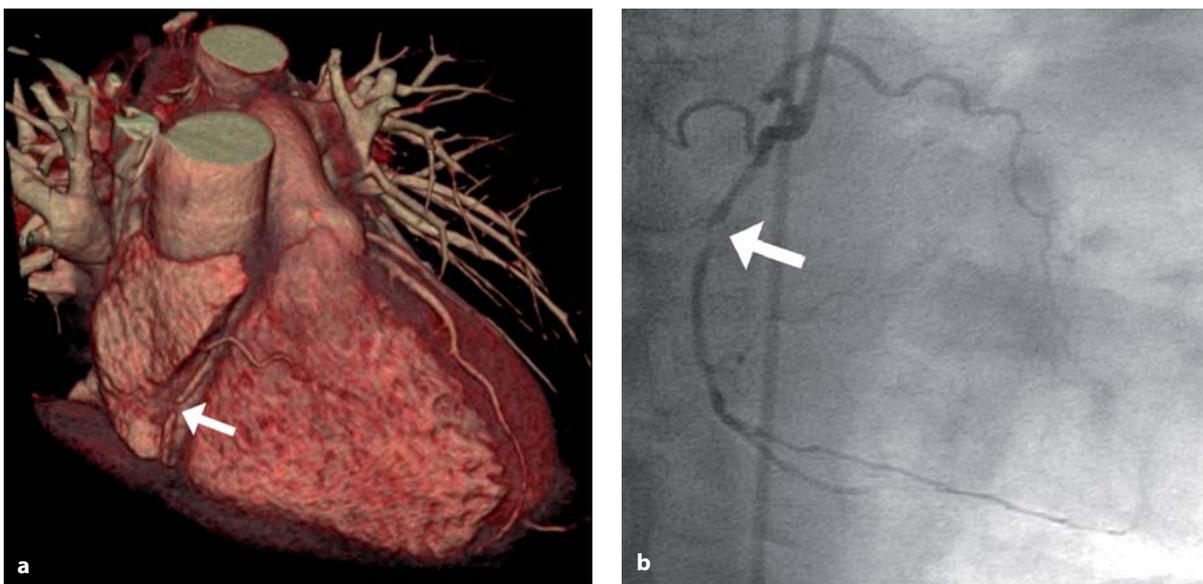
a, b. The robustness of 64-slice CT includes its ability to present detailed findings. Short-term coronary-artery stenosis in the right coronary artery in (a) the CT volume-rendering image and (b) conventional coronary angiography
